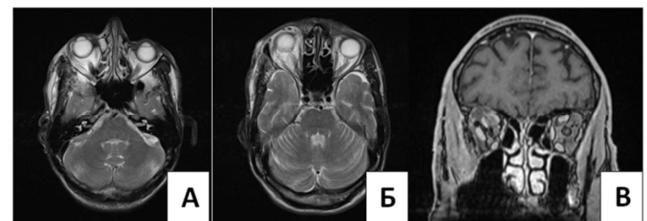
Patient's contrast-enhanced MRI images obtained in 24-hours post right-sided osteoplastic orbitotomy.
